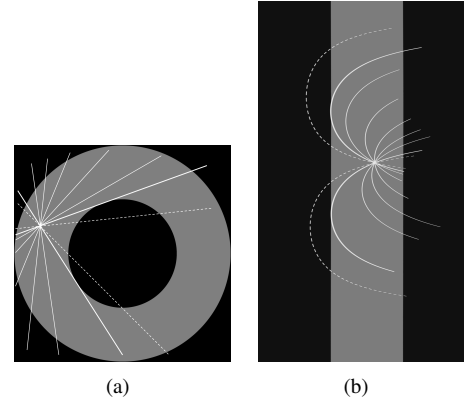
The x-ray paths in Cartesian coordinate system and polar coordinate system. The x-ray path along the straight line in Cartesian image (a) corresponds to the path along the corresponding curve in polar image (b).
